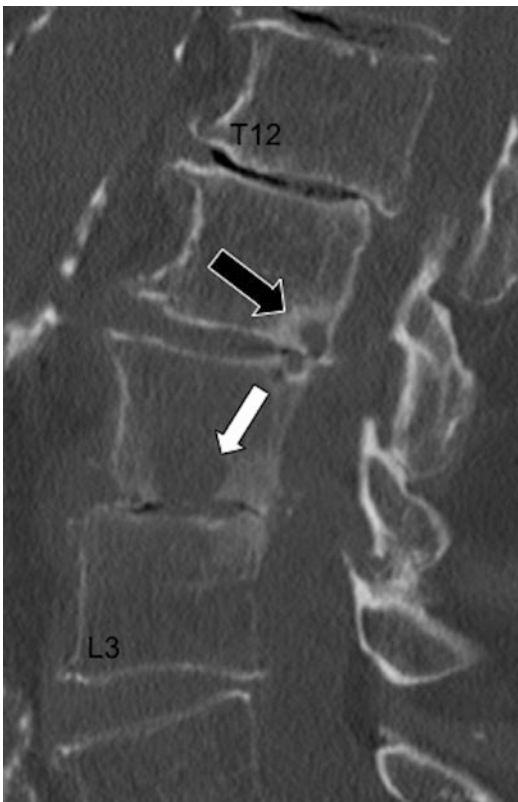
Sagittal CT image of the lumbar spine demonstrates disc height loss at L2–L3 with focal acute erosion at the L2 endplate (white arrow). A non-infectious degenerative sub-endplate cyst at the posterior L1 vertebra can be differentiated from the infectious erosion by the clearly defined sclerotic rim (black arrow)
